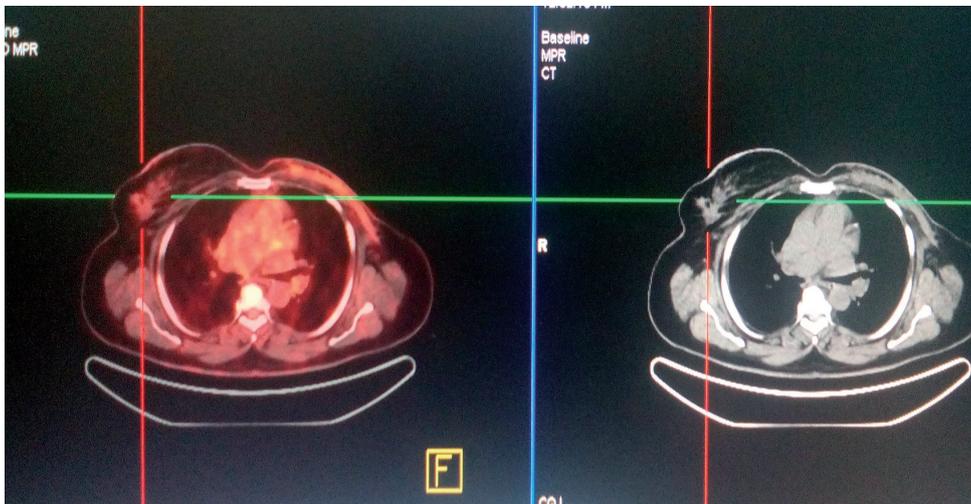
Axial PET-CT and CT images of patient categorized as a true positive.
